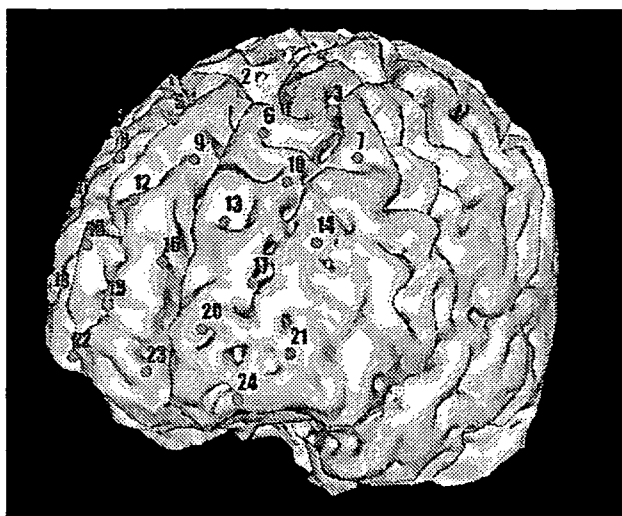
NIRS measurement points superimposed on a representative subject's 3D-MRI.
